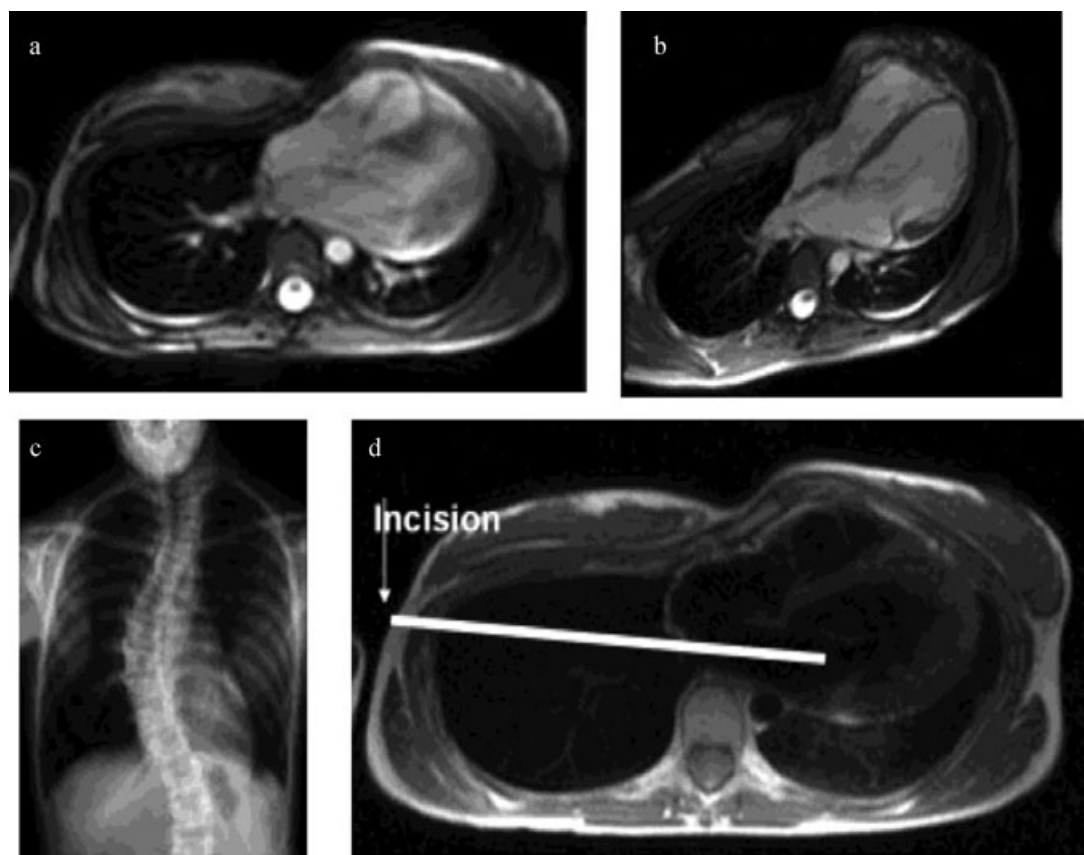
Minimally invasive mitral valve repair of a Marfan patient with severe kyphoscoliosis and pectus excavatum. (a) and (b): Magnetic resonance imaging (MRI) scans showing severe pectus excavatum; (c) X-ray showing a severe kyphoscoliosis; (d) MRI-based planning of the incision before anterolateral or midlateral minithoracotomy. In this 26-year-old female patient, sternotomy is aggravated and with an increased risk due to a severe kyphoscoliosis and pectus excavatum. MRI is done for planning the optimal access to the left atrium and exposure of the mitral valve. Minimal access repair is done with video-thoracoscopic assistance. The white bar indicates the planned incision and view on the mitral valve.
